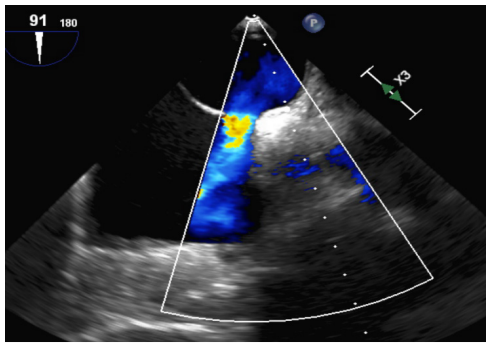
Transesophageal echocardiogram view showing the atrial septal defect.
